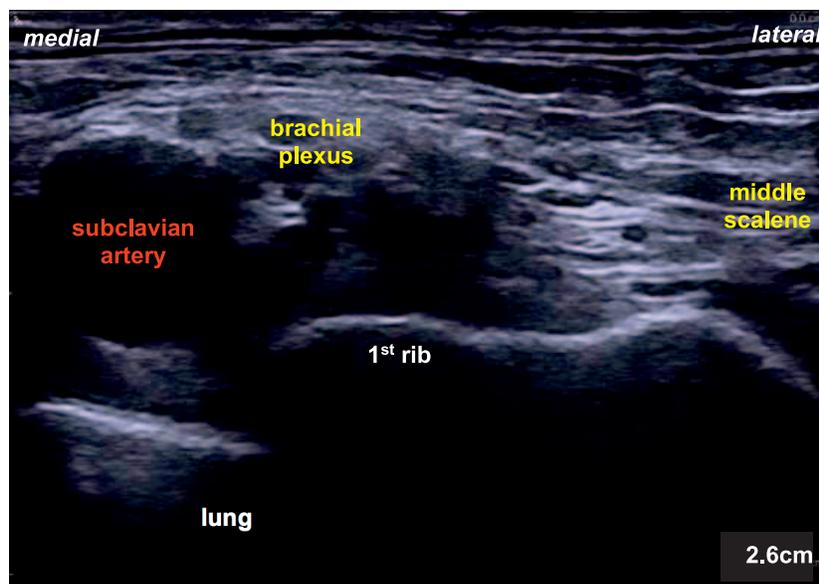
Ultrasound image demonstrating the relationship of the relevant structures in the supraclavicular fossa.
